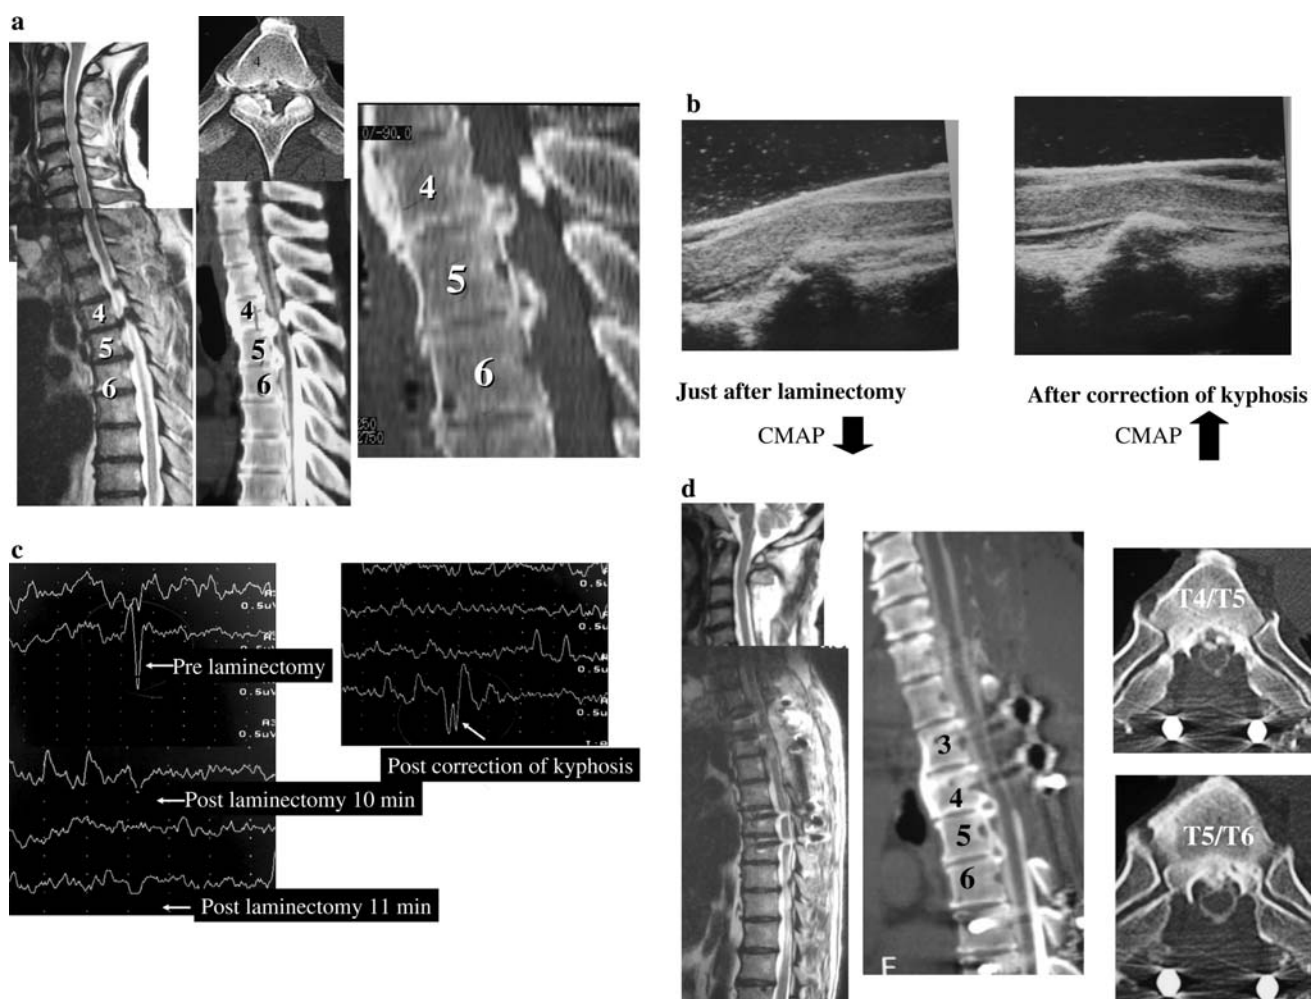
a MRI and myelo CT. Cervical canal stenosis from C3 to C7 and beak-type OPLL of T4/T5 and T5/T6 were detected. Severe spinal compression by OYL and OPLL was noted at T4/T5. b Intraoperative ultrasonography after laminectomy and after correction of kyphosis. On ultrasonography immediately after laminectomy, the spinal cord was raised by OPLL in the anterior region. The spinal cord was free from OPLL after correction of kyphosis. c CMAP
